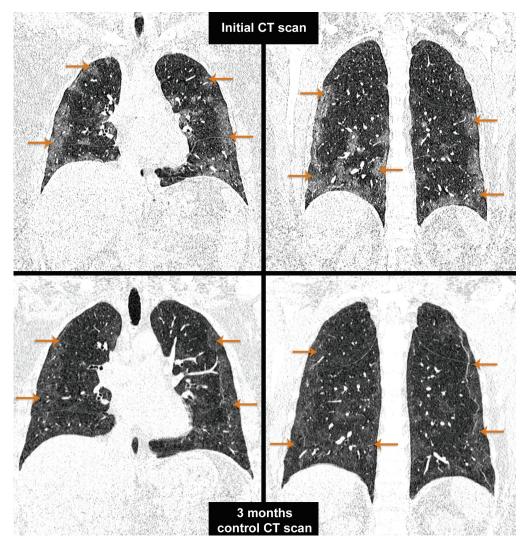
CT scan—initial vs. control (3-month follow-up after hospitalization).
